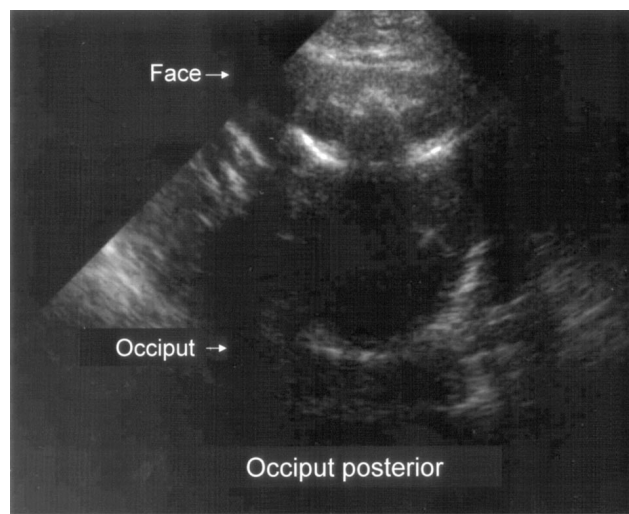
Ultrasound image of fetus in the occiput posterior position.
